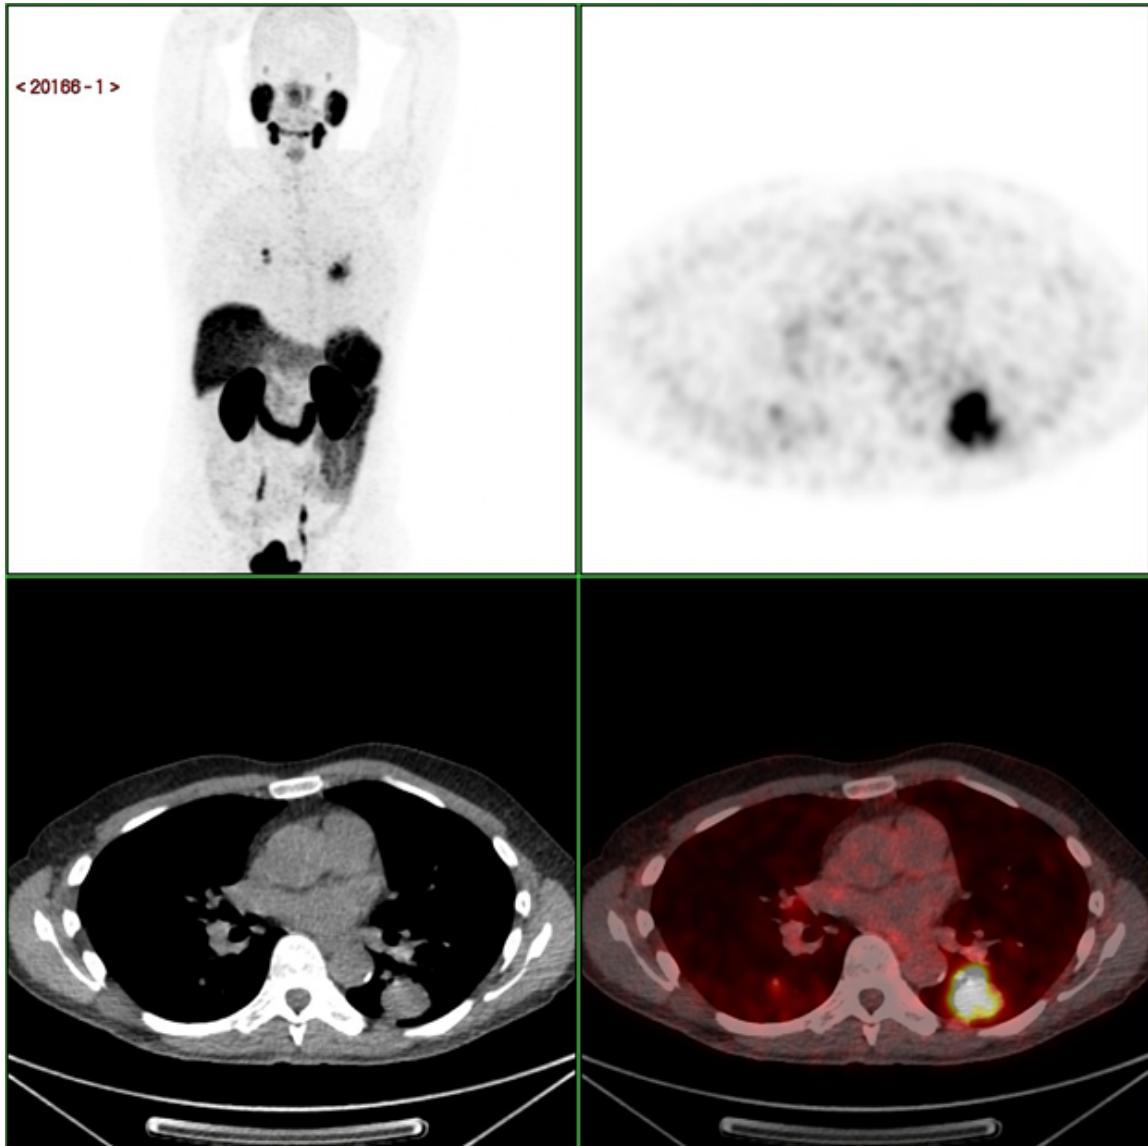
^{68}Ga PSMA PET/CT MIP, axial PET, low dose CT and PET/CT in a 75 years old patient with biochemical relapse following radiotherapy (PSA 9.2). There are bilateral lung nodules, largest in the apical segment of the left lower lobe with intense tracer uptake. These findings are in keeping with metastatic disease
